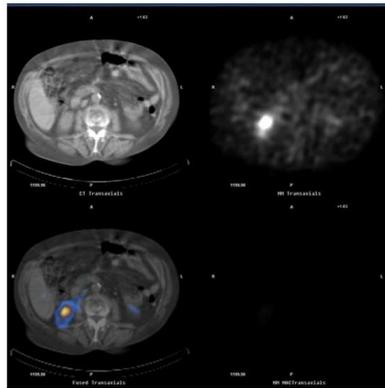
Patient with *Mycobacterium tuberculosis* infection of the L3 body. Transaxial CT, SPECT and fused sections showing no obvious ^{111}In -Biotin accumulation at the infection site (false-negative result)
